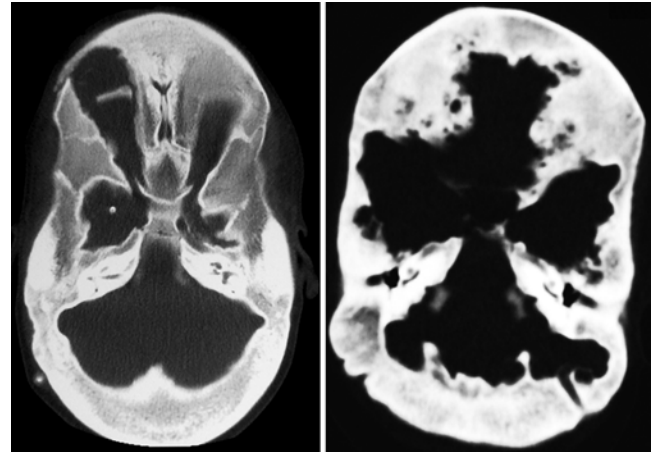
Case 1 (left) and Case 2 (right). Computed tomography scans of the skull showing thickening of the diploe, dolichocephaly, sclerosis of the skull base, and severe stenosis of the skull base foramina in both cases.
